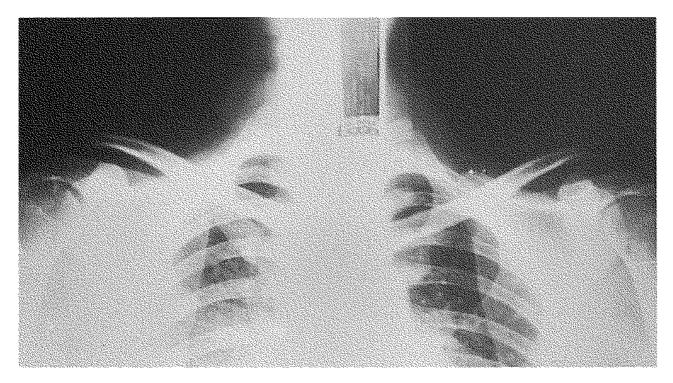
Xray after reduction of both dislocations.
